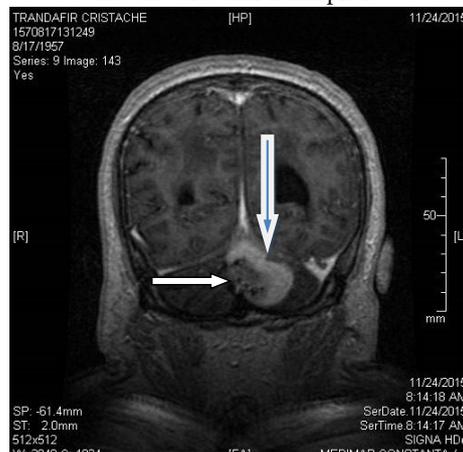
Preoperative aspect. Cerebral MRI, T1 with Gadolinium coronal incidence: Central vermian and left paravermian heterogeneous lesion, with a posterior and central part of about 2,2/1,5 cm hypointensity, having inside small hyperintense areas (white arrow). Adjacent, superior vermian and left paravermian subacute haematoma (white and blue arrow)
